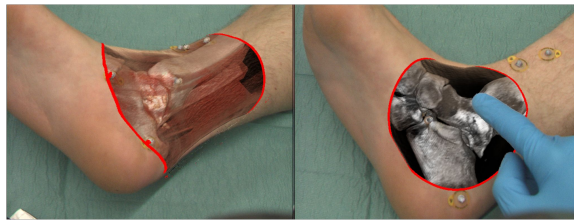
Augmented reality visualization of a 3D rendered CT data set with different transfer functions and algorithm to avoid overlaying virtual data on surgical hand shoes. Image courtesy of Dr. Oliver Kutter from the Chair of Computer Aided Medical Procedures at TUM.
